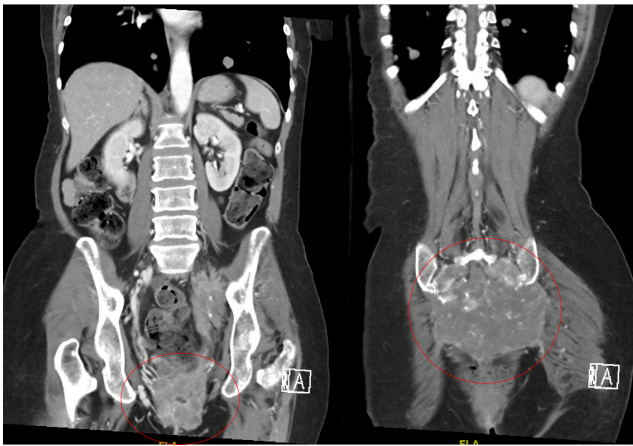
CT chest/abdomen/pelvis with and without contrast. Coronal plane images with a red circle showing large circumferential soft tissue mass extending to perineal soft tissues, vaginal cuff, and left gluteal fold (left panel). Large destructive soft tissue mass with significant osseous destruction of the sacrum and coccyx (right panel).
